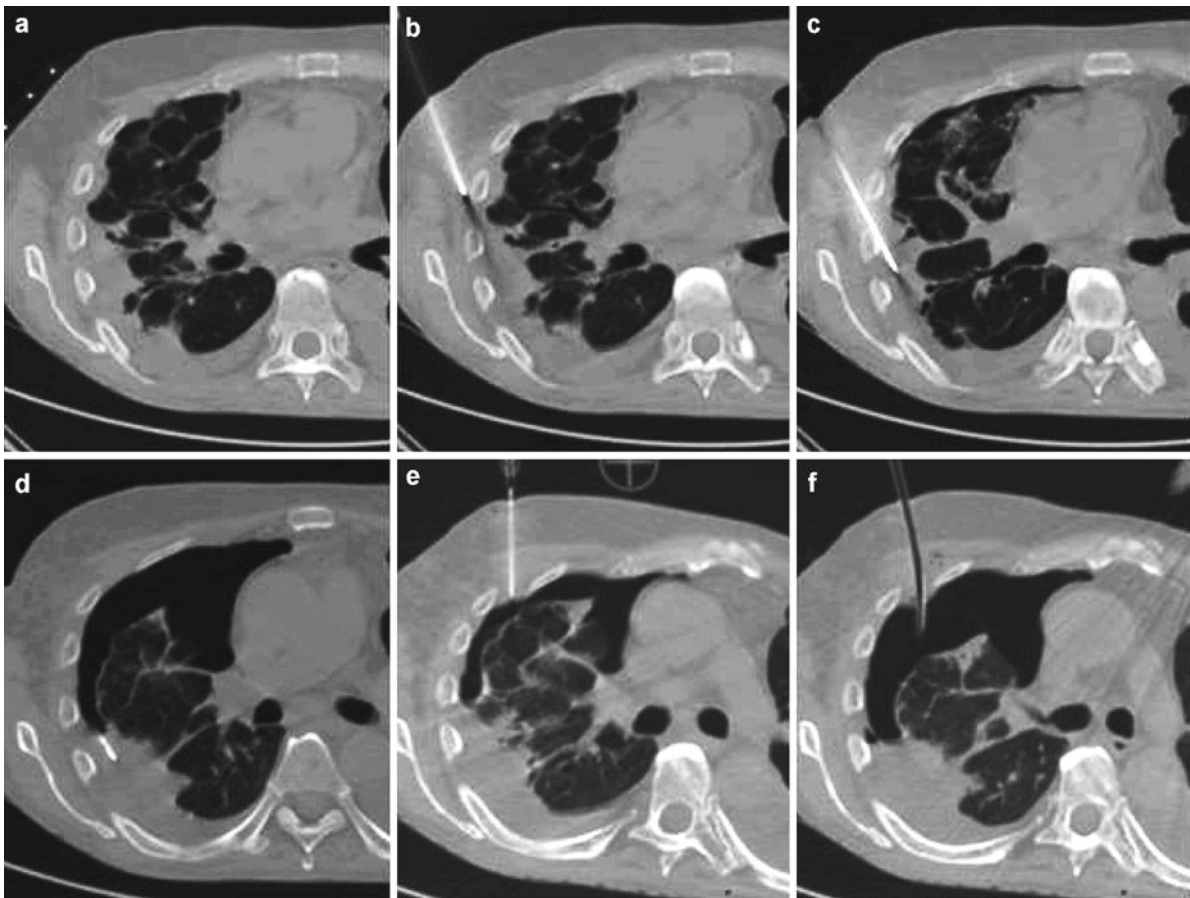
CT-guided lung biopsy in a 55-year-old patient after allogeneic bone marrow transplantation for lymphoma. The target lesion is located less than 2 cm from the thoracic wall. Despite careful needle placement, a large pneumothorax
